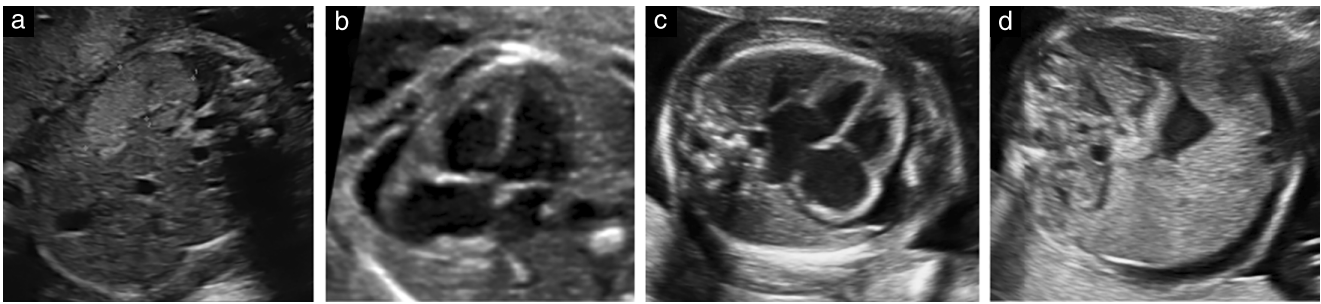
Ultrasonographic extracranial features typical of CMV infection vary, and include: splenomegaly (a), cardiomegaly (b,c), pericardial effusion (b,c), hydrops (c) and ascites (d).
